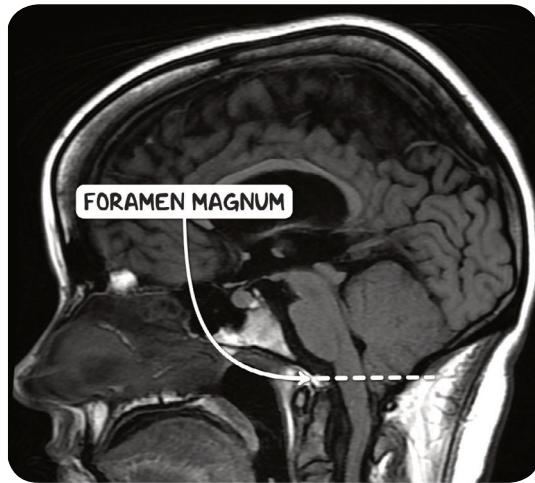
An MRI scan of the head in the sagittal plane of an individual with an Arnold-Chiari malformation. There is a small posterior fossa and partial descent of the brainstem and the cerebellar tonsils through the foramen magnum.
